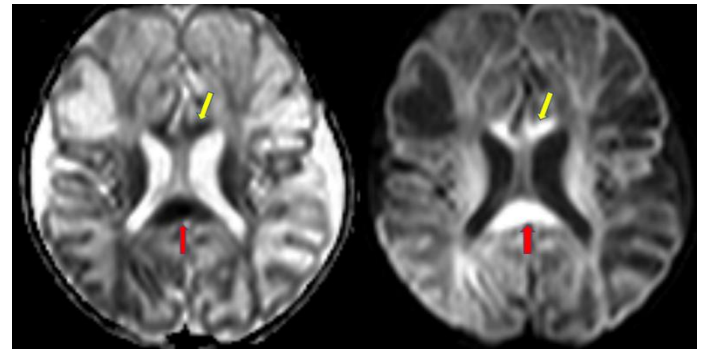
Axial DWI and ADC image showing diffusion restriction involving genu (yellow) and splenium (red) of corpus callosum
